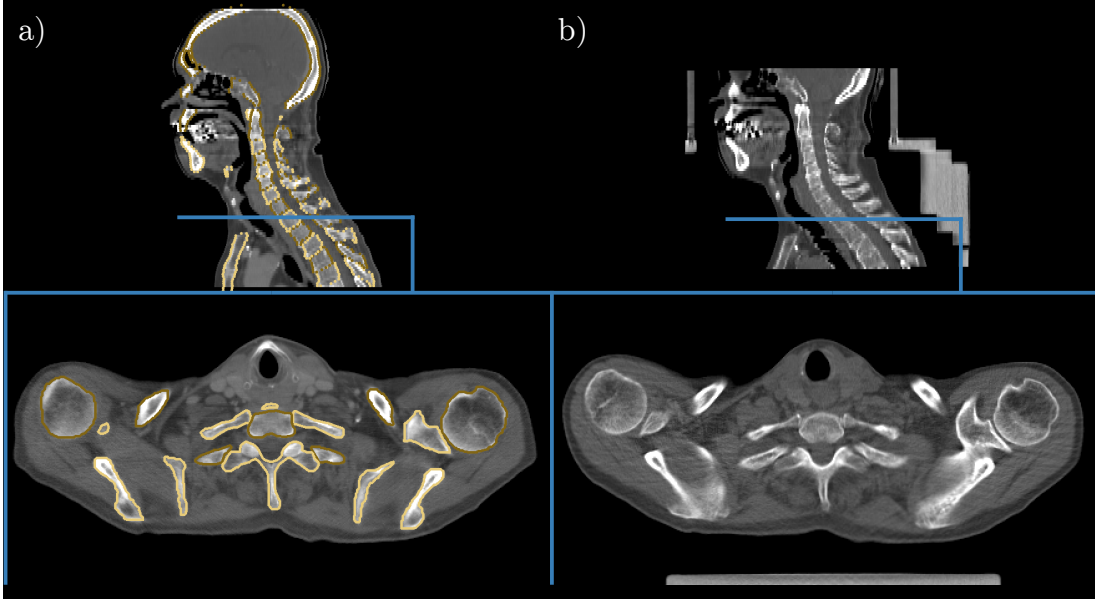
Image quality of CT slices for patient 1_{CT} . a) A sagittal and transversal slice of the planning CT indicating the measured field-of-view and the used manual bone segmentations. The blue line indicates the position of the transversal slice. b) The stereotactically aligned corresponding slice of a fraction CT (F01). The chosen fraction scan is representative of the imaging quality of all fraction scans, facilitating meaningful accuracy of manually identified correspondence points.
